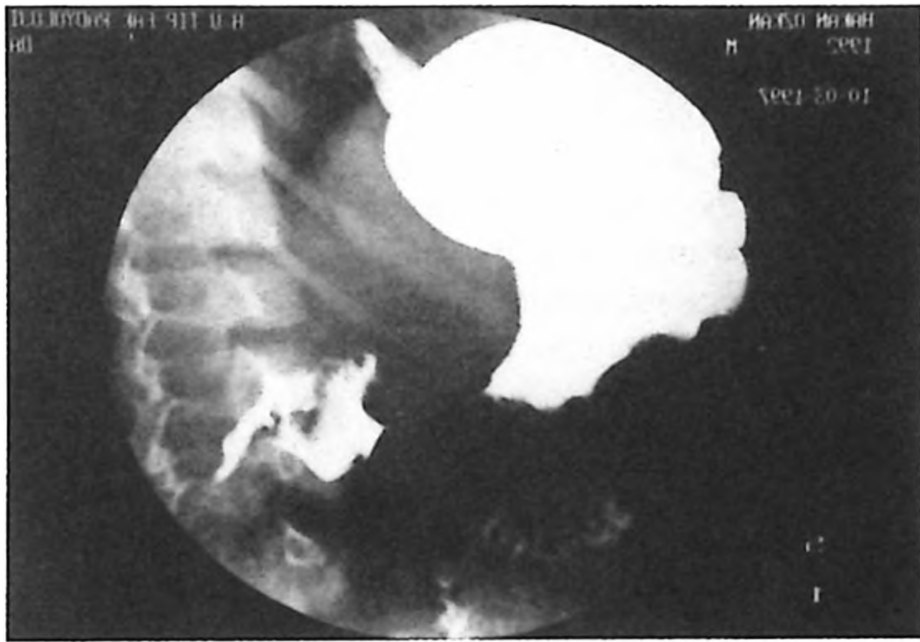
Upper gastrointestinal radiography shows nearly complete gastric outlet obstruction.
